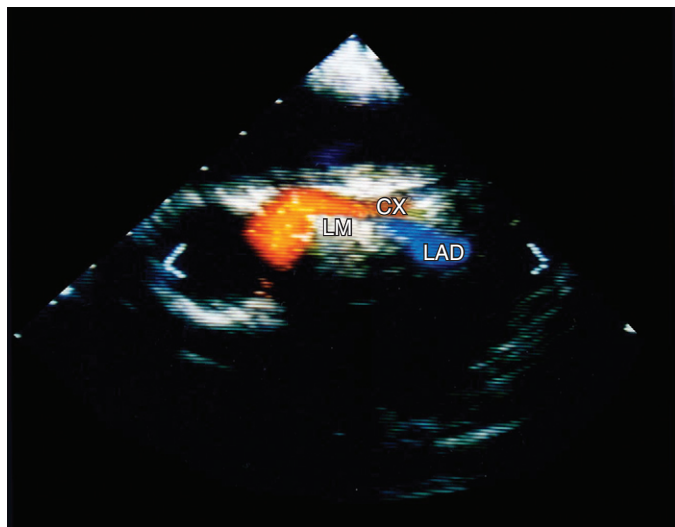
Transesophageal echocardiography shows flow in the left main (LM) coronary artery and its bifurcation, left anterior descending (LAD) artery, and circumflex (CX) artery.
